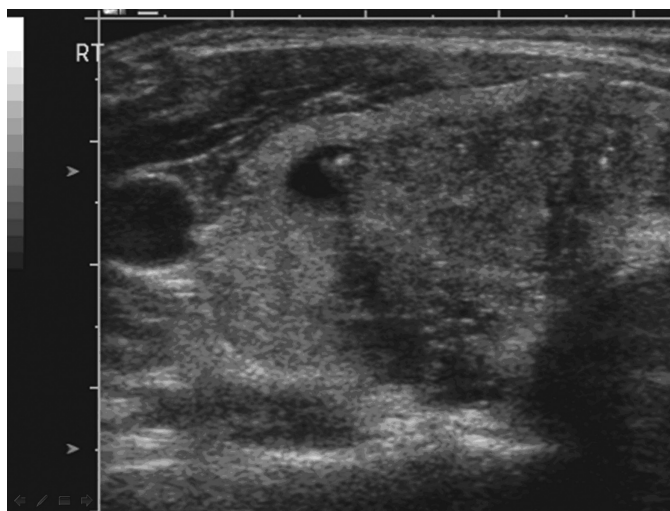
Ultrasound of PTC with calcifications and irregular margins (courtesy of Dr PS Sidhu, Radiology, King's College Hospital, London).
